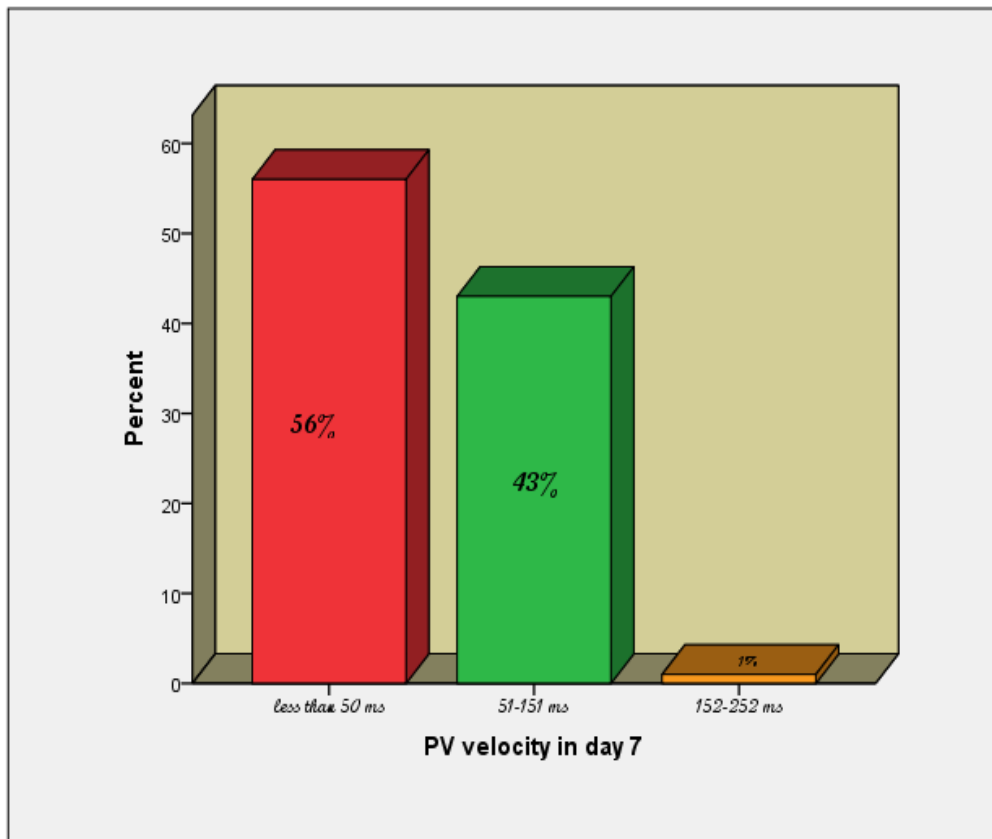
Frequency distribution of spectral Doppler for portal vein in day 7
